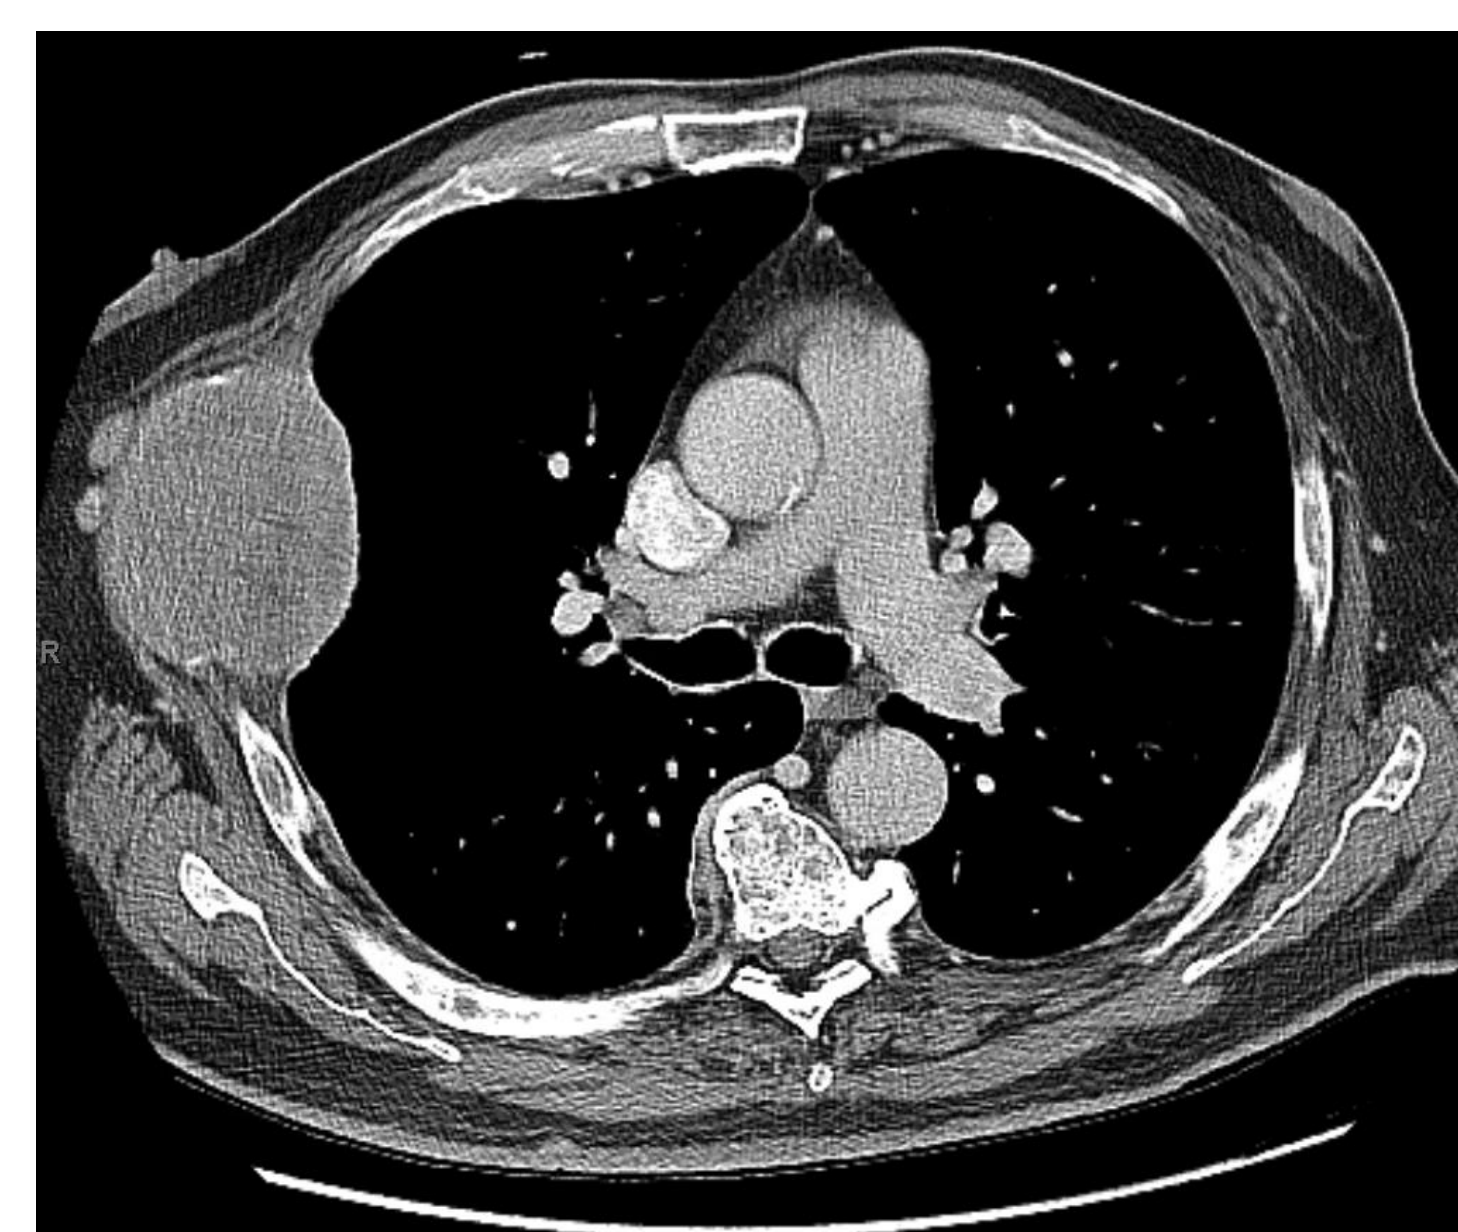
CT chest demonstrating soft tissue mass along right lateral chest wall measuring 8.5 x 7.0 cm.
